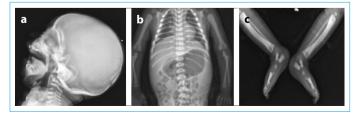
(a) The base of the skull and facial bones are sclerotic. (b) Diffuse sclerosis is present within all bones. There is metaphyseal widening and undermodeling. Metaphyseal lucent bands are seen at the ends of long bones. (c) Anterior-posterior radiographs of lower limbs demonstrate "bone-within-bone" appearance in the long bones, tarsal bones, and short tubular bones of feet.
